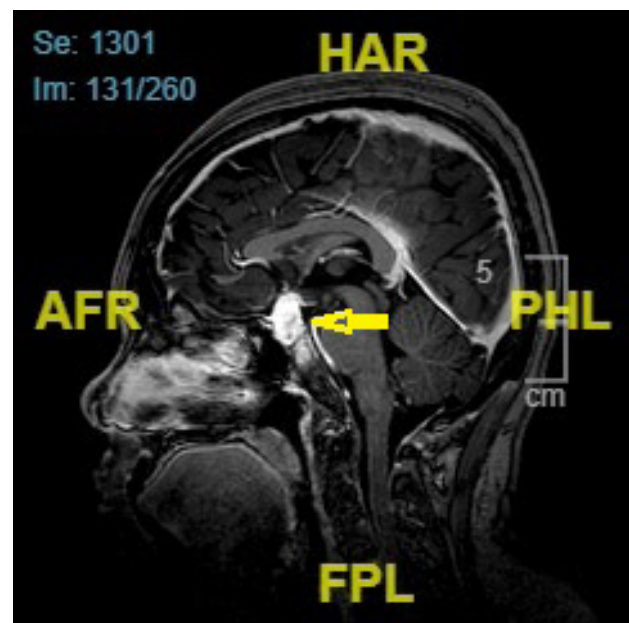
T1-weighted Magnetic Resonance Brain (MRI) of the brain revealed a lobulated pituitary macroadenoma with suprasellar extension (Yellow arrow)
